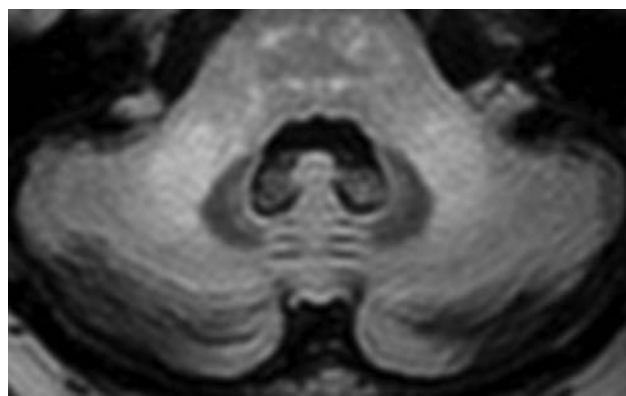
Patient 2. A FLAIR axial image shows bilateral high signal intensities in the middle cerebellar peduncle.
